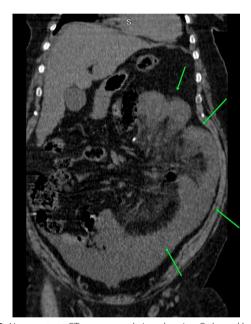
Non-contrast CT scan coronal view showing C-shaped loop of bowel in the coronal cut section
